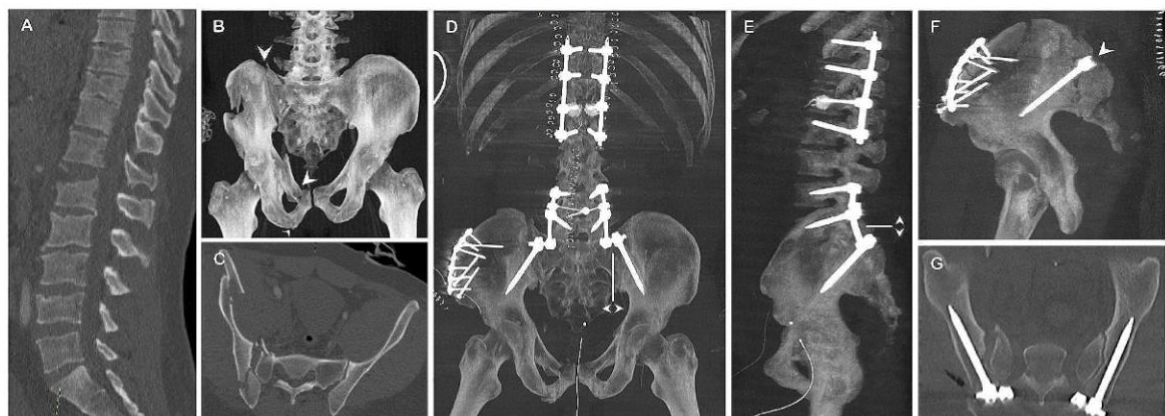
(a to c) Preoperative and (d to g) postoperative computed tomography scan. (a) T12-L1 AO Spine B3 thoracolumbar trauma on sagittal view. (b, c) Right-sided Tile C vertical shear pelvic ring disruption with (b, upper white arrowhead, and (c) posterior spinopelvic instability, (b, lower white arrowheads) anterior pelvic ring disruption. (d, e) Postoperative computed tomography scan, maximum intensity
